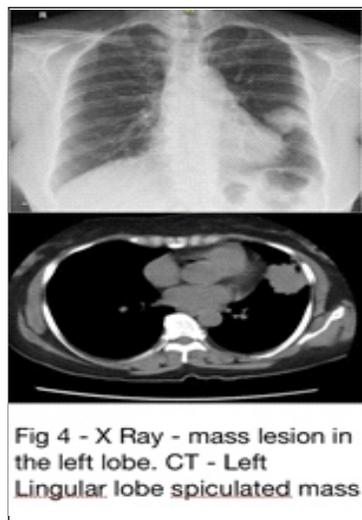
X Ray - mass lesion in the left lobe. CT - Left Lingular lobe spiculated mass
